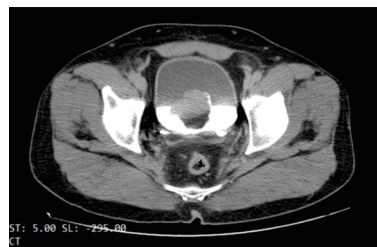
CT image with contrast showing irregular growth in the urinary bladder
